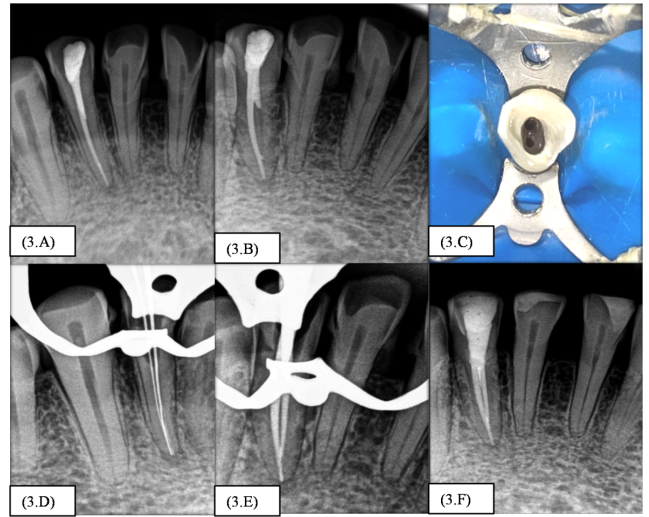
Case report 2: Missed canal in Mandibular lateral incisor (42); A: Pre-operative radiograph; B: Mesially angulated radiograph revealing the missed canal; C: Access cavity preparation; D: Working length determination; E: Master cone GP fit radiograph; F: Post-operative radiograph at 1 year follow-up
